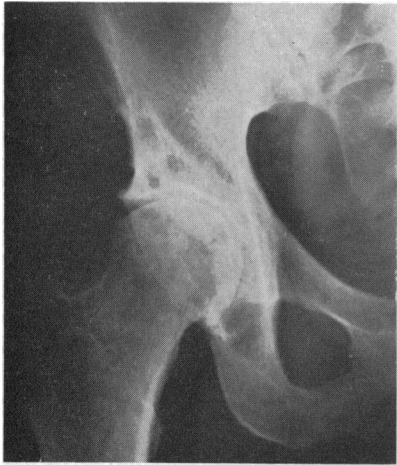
Radiograph of right hip in 1951. Note moderate osteoarthritic changes.
